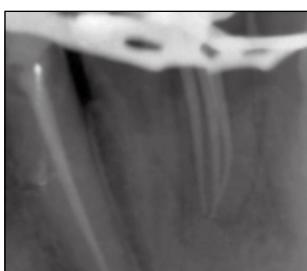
A postobturbation radiograph of teeth No. 25 and 26.
